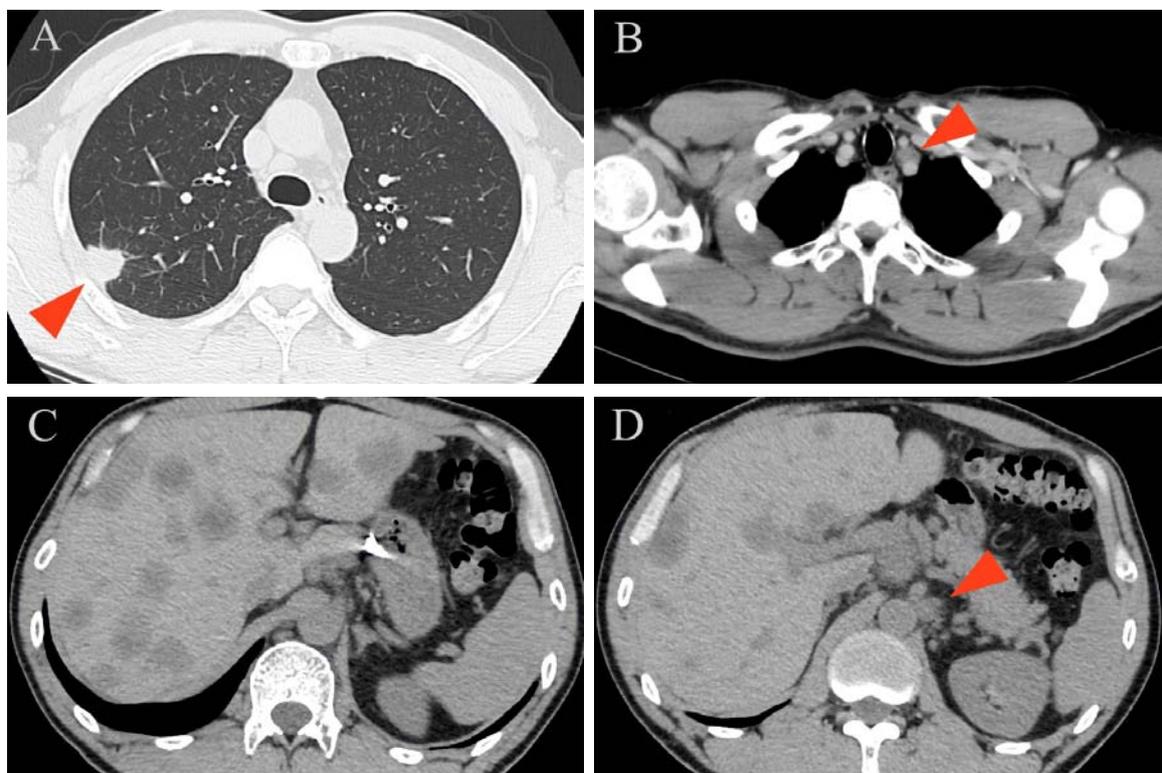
Chest and abdomen CT findings. A: Chest CT showed a 19 mm mass in the upper lobe of the right lung (arrowhead). B: Multiple liver metastases across both lobes. C: Para-aorta lymph node metastasis was positive (arrowhead). D: Contralateral mediastinal lymph node metastasis was also positive (arrowhead).
